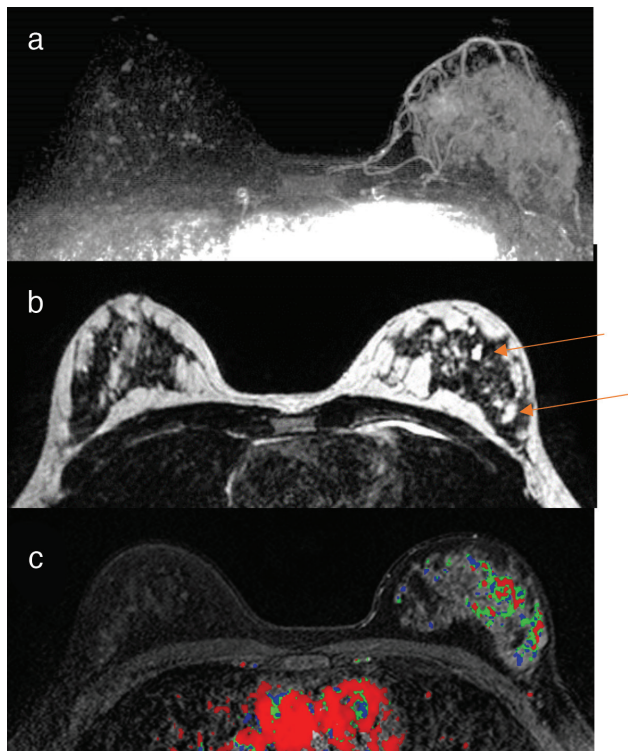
A 47-year-old pre-menopausal woman with a strong family history of breast cancer undergoing annual MRI screening. Figure reveals axial dynamic contrast-enhanced (DCE) MRI findings. (a) Maximum intensity projection (MIP) reveals cancer occupying a substantial portion of her left breast, (b) T2-weighted imaging reveals associated cysts (arrows) consistent with the micropapillary component, and (c) dynamic early subtraction image with overlying time intensity map. There is diffuse, non-mass-like enhancement involving all four quadrants of the left breast with no evidence of nipple involvement or axillary lymphadenopathy identified in the remainder of the MRI study.
